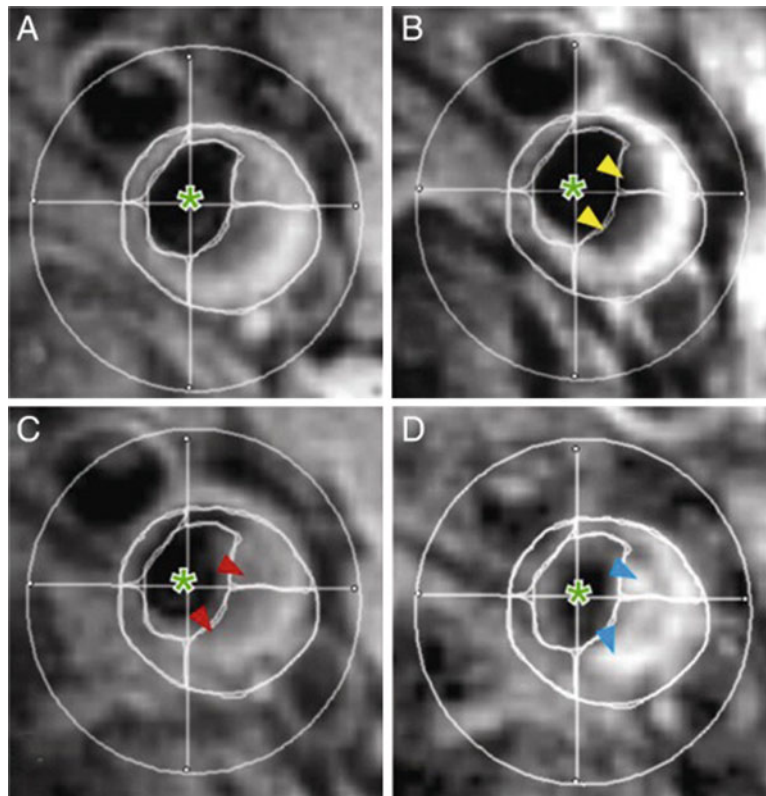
T2*-weighted MRI images of the right common carotid artery of a patient receiving 12 weeks of high-dose atorvastatin (80 mg) treatment. Images were taken before (left) and after (right) ultrasmall superparamagnetic iron oxide (USPIO) infusion at time points 0 (a and b) and 12 weeks (c and d). (b) USPIO uptake can clearly be seen in the plaque at baseline (yellow arrowheads). (c) USPIO has been cycled out of the plaque before reinfusion at 12 weeks (red arrowheads). (d) The plaque enhances at 12 weeks (blue arrowheads), indicating
